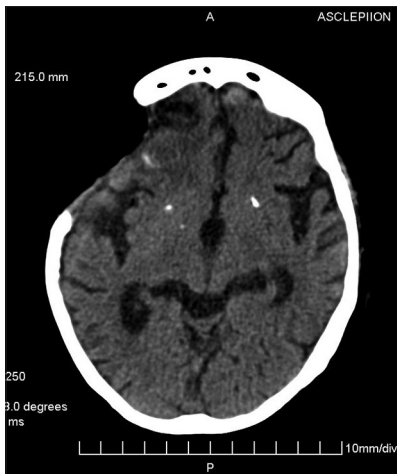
Postcontrast computed tomography scan 3 weeks after surgical procedure reveals the intracranial infections decreased
